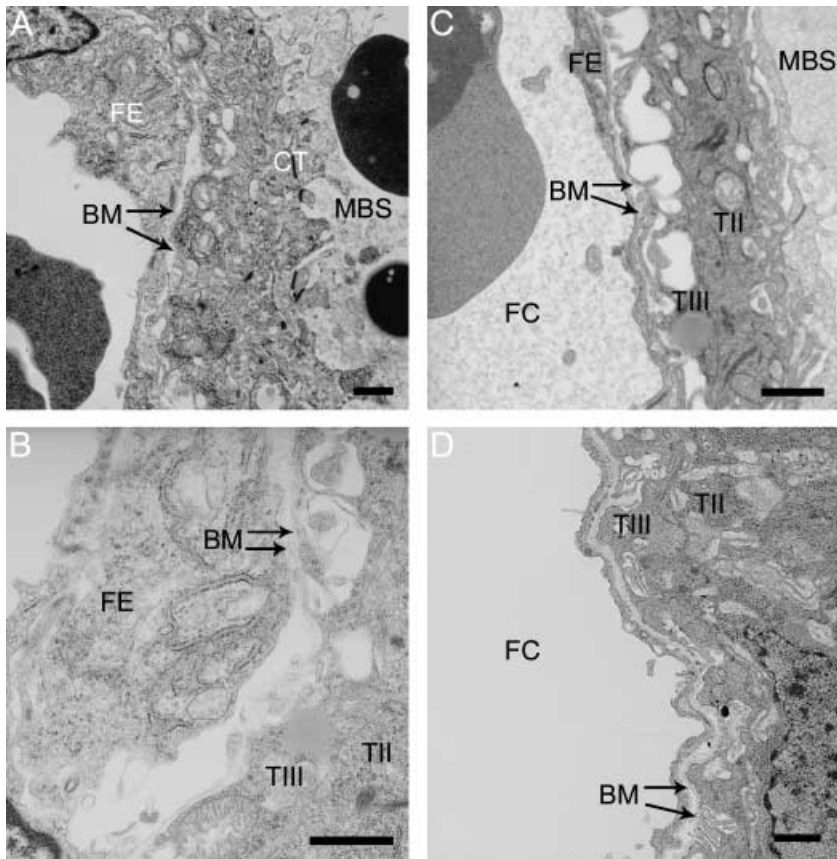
Areas of the interhaemal membrane where two separate basement membranes (BM) can be clearly identified associated with the fetal endothelium (FE) or syncytial trophoblast (TIII) surrounding the fetal capillary (FC). (A) E12.5, (B) E14.5, (C) E16.5, (D) E19.5. CT, cytotrophoblast; MBS, maternal blood space; TII, syncytial trophoblast Layer II. Scale bar = 1 µm.
